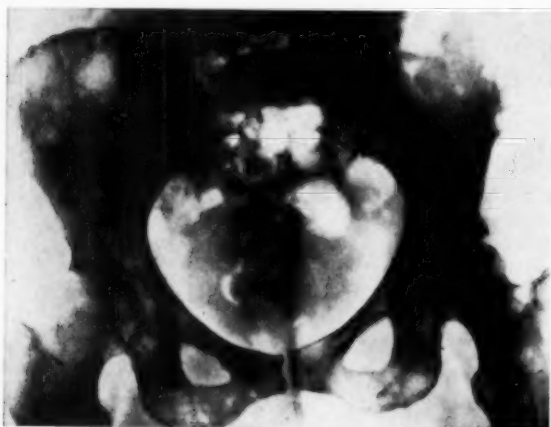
X-ray of pelvis on 6 July 1954.
